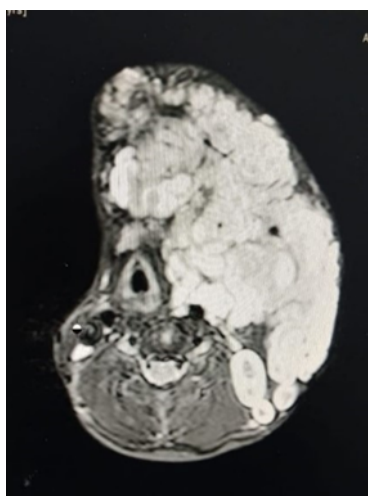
MRI of neck showing tumor encroaching the oropharynx and causing deviation of the glottis
